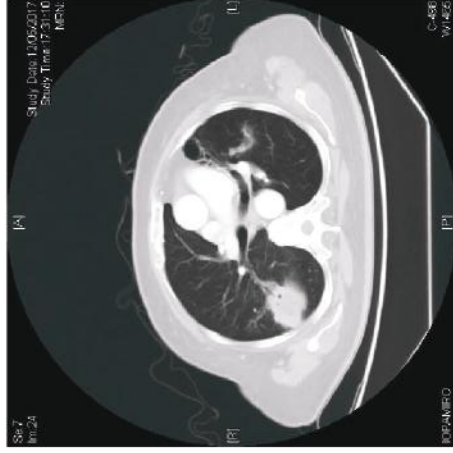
CT thorax in the first hospitalization
